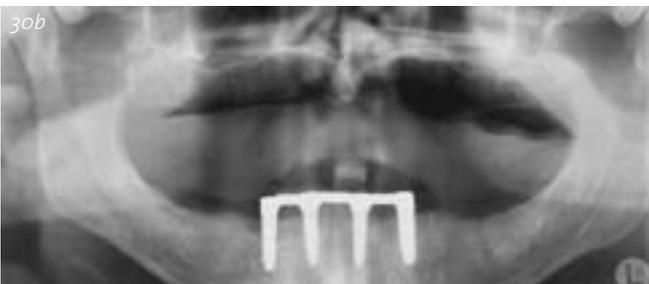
Panoramic radiograph: Check of implant positions and coupling between prosthetic components.
